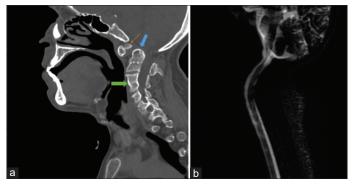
(a) Sagittal bone window CT depicts an os odontoideum (thin orange arrow), expanded and globular shape of the odontoid process of C2 vertebra (block blue arrow), and fused C3 and C4 vertebral bodies (block green arrow). Posterior elements of C3 and C4 vertebrae were also fused (not shown). Increased atlantodens interval can be appreciated; (b) sagittal MR myelogram image of the same patient shows severely thinned spinal cord at the cervicomedullary junction
